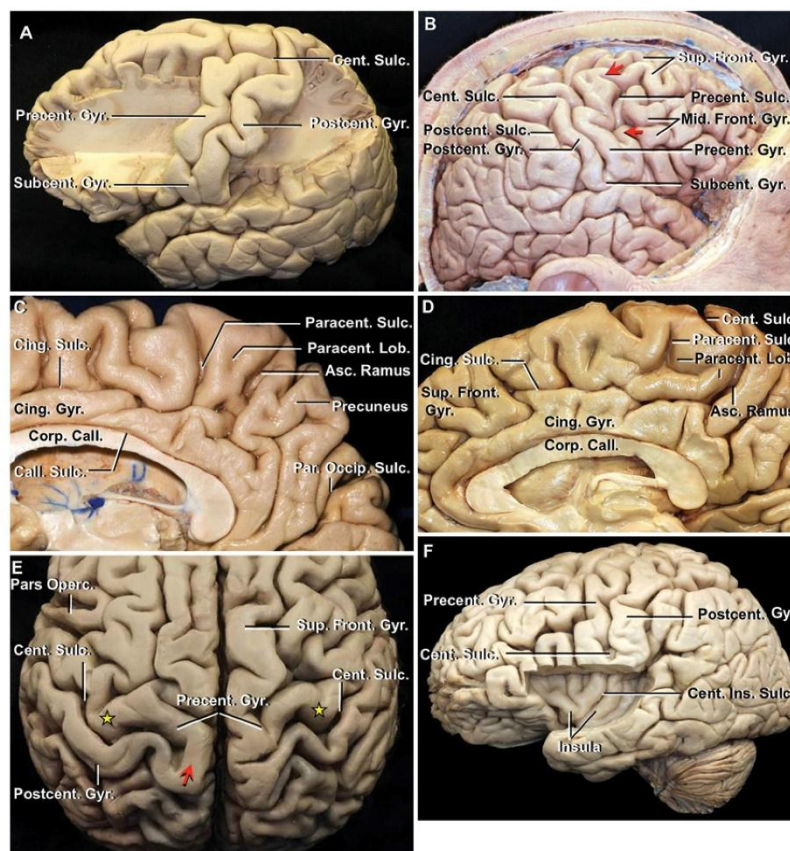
Gyral and sulcal variations in multiple hemispheres. A: Part of the frontal and parietal lobes has been removed while preserving the pre- and postcentral gyri separated by a central sulcus. The central sulcus commonly opens directly into the interhemispheric fissure but is separated from the sylvian fissure by a gyral bridge, the subcentral gyrus. It has a gently convex posterior upper curve and a gently convex anterior lower curve. The shallow indentation on the subcentral gyrus is not a sulcus but is related to an artery crossing the gyrus. B: Gyral bridges frequently interrupt the precentral and postcentral gyri but not the central sulcus (Table 1). The postcentral sulcus in this hemisphere is continuous and not interrupted by any gyral or sulcal bridge. The central sulcus opens into the interhemispheric fissure but is separated from the sylvian fissure by a subcentral gyrus. Two complex gyral bridges (red arrows) connect the superior and middle frontal gyri to the lower part of the precentral gyrus. C and D: Medial surface of two right hemispheres. C: The paracentral lobule is formed by the extension of the pre- and postcentral gyri onto the medial surface of the hemisphere. The paracentral lobule is limited posteriorly by the ascending ramus of the cingulate sulcus and anteriorly by the paracentral ramus of the cingulate sulcus. The paracentral sulcus was present in approximately half of hemispheres. The ascending ramus was found in nearly all hemispheres and is easily seen on MRI at the posterior edge of the paracentral lobule. The precuneus is located between the ascending ramus and the parietooccipital sulcus. D: The paracentral sulcus, which was absent in approximately 50% of hemispheres, does not reach the upper margin of this hemisphere. The anterior limit of the paracentral lobule can be determined by the overlap of the central sulcus onto the medial surface. E: Superior view. On the left hemisphere there is a large gyral bridge (red arrow) connecting the upper edges of the pre- and postcentral gyri and separating the upper end of the central sulcus from the interhemispheric fissure. The "hand knob" on the precentral gyrus is seen in both hemispheres (yellow stars). F: Lateral surface. The lower third of the central sulcus usually courses lateral and parallel to the central insular sulcus. Asc. = ascending; Cent. = central; Cing. = cingulate; Corp. Call. = corpus callosum; Front. = frontal; Gyr. = gyrus; Ins. = insular; Lob. = lobule; Mid. = middle; Occip. = occipital; Operc. = opercularis; Par. = parietal; Paracent. = paracentral; Postcent. = postcentral; Precent. = precentral; Subcent. = subcentral; Sulc. = sulcus; Sup. = superior.
